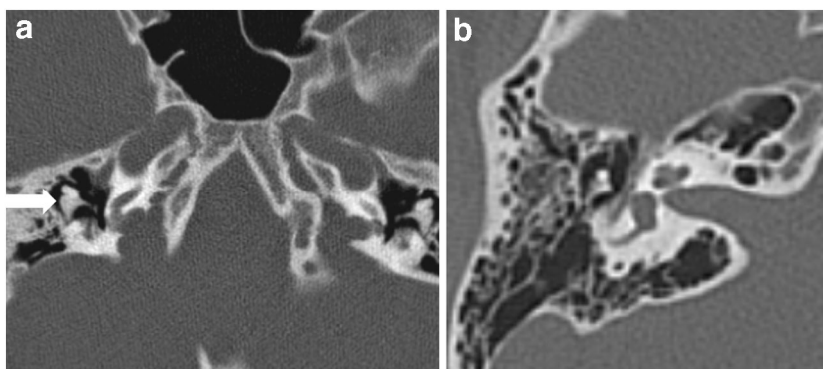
Broad ice-cream cone sign in the same 15-year-old girl as in Fig. 6. a Coronal CT reconstruction demonstrates that the incus appears thicker and shorter, namely as a "broad ice-cream cone" (arrow), from the rotation of ossicles. b Coronal reconstructed CT image of a normal child for comparison shows a normal ice-cream cone appearance
